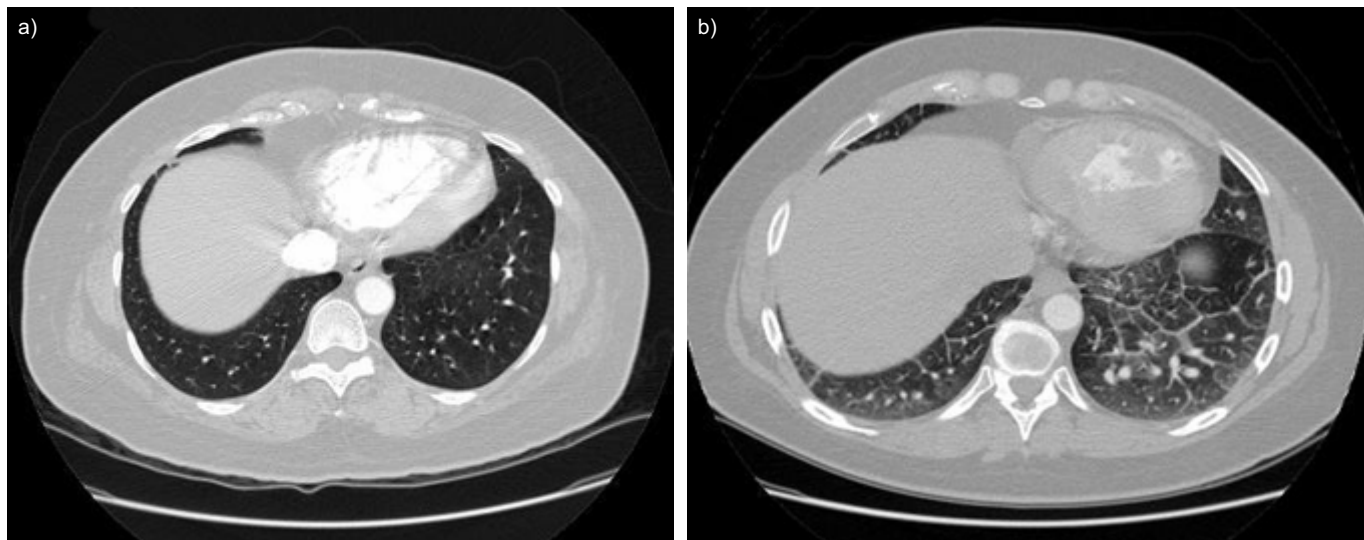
High-resolution computed tomography scans of the chest in pulmonary arterial hypertension. a) Normal lung appearances in a patient with idiopathic pulmonary arterial hypertension. b) Lung appearances of pulmonary veno-occlusive disease with interlobular septal thickening against a ground-glass background.
